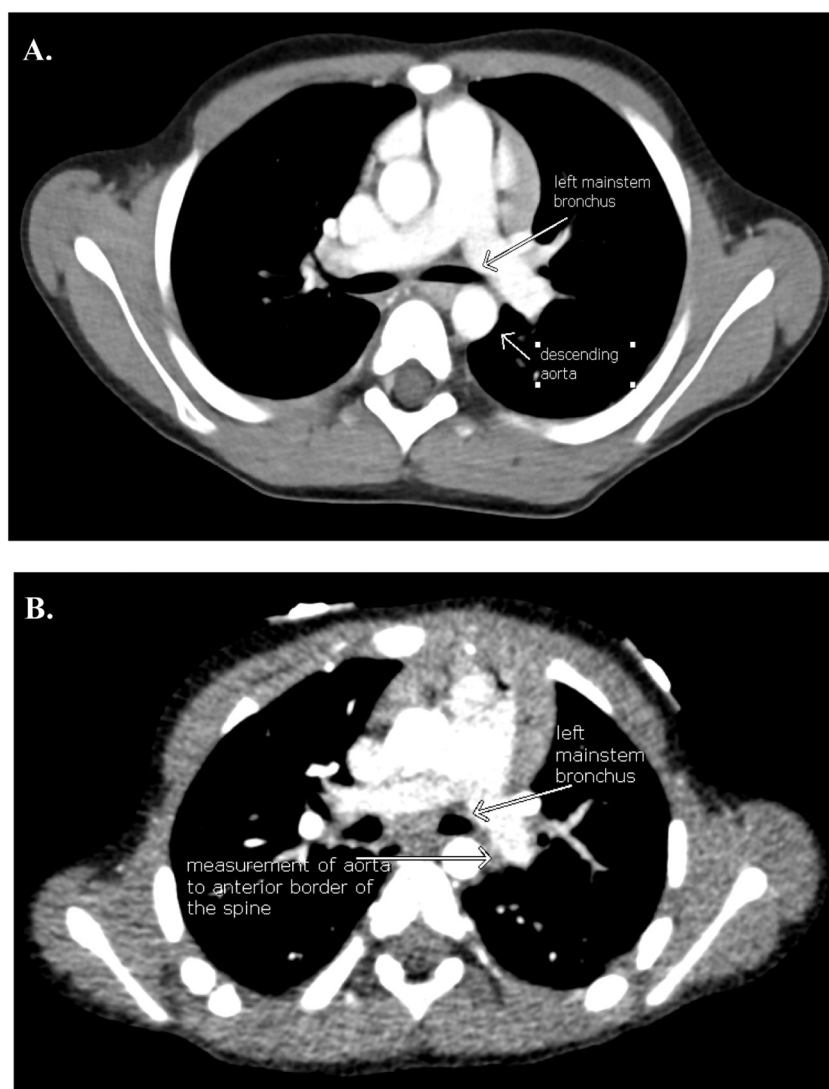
(A–D) CT images representing the four categories used to describe the location of the descending aorta compared to the anterior border of the spine (ABS). Measurements were performed at the level where the left mainstem bronchus crosses anterior to the aorta. (A) Less than 25% of the descending aortic diameter is located anterior to the ABS. (B) 50% of the aortic diameter is located anterior to the ABS. (C) Between 50% and 75% of aorta is located anterior to the ABS. (D) The entire aorta is anterior to the spinal column. This patient also has a right aortic arch.
